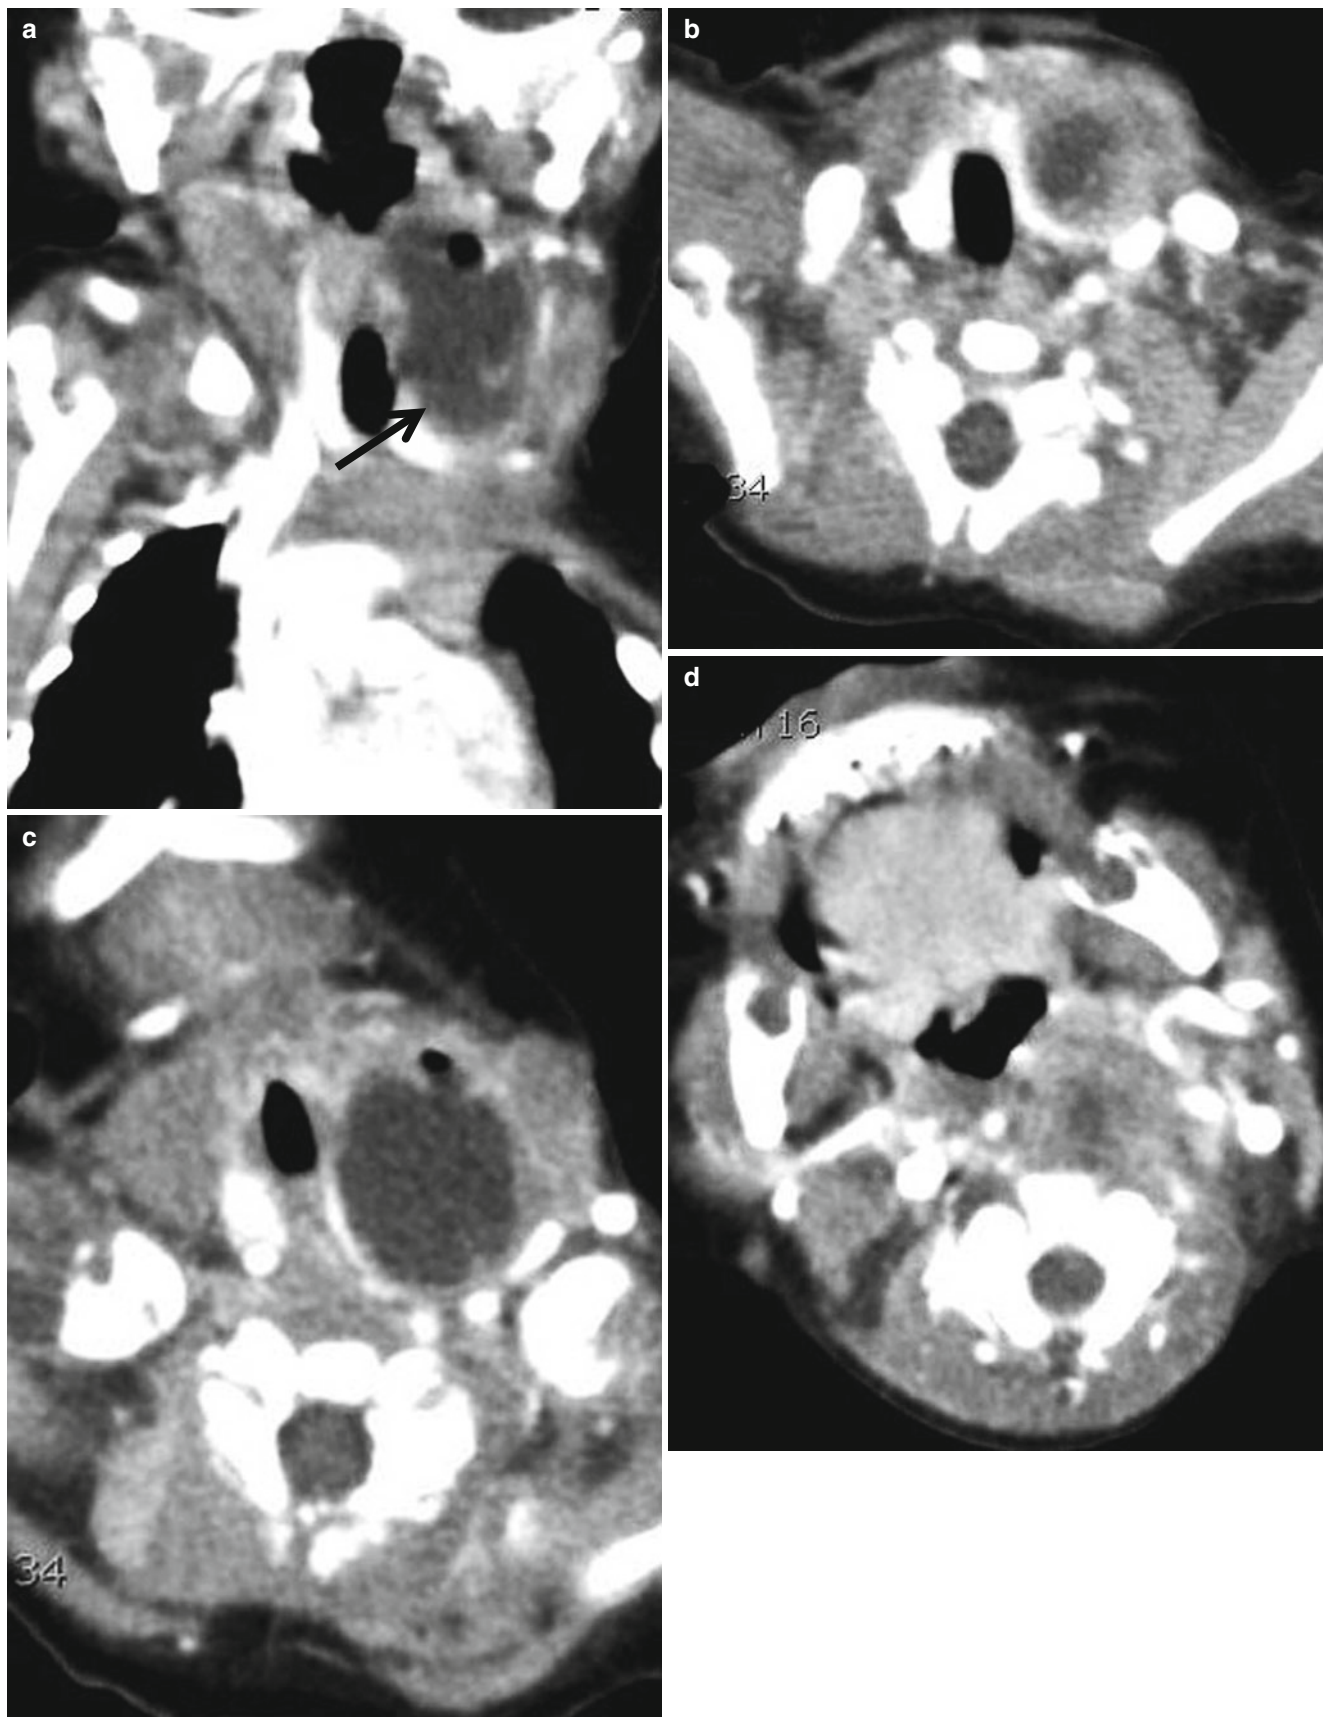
Fourth branchial cleft cyst with a sinus in a 2-month-old infant. (a) Coronal reformatted CT scan shows an air-containing elongated cystic mass from the level of the pyriform sinus to the left low neck abutting the left thyroid gland (*arrow*). (b–d) Contrast-enhanced
